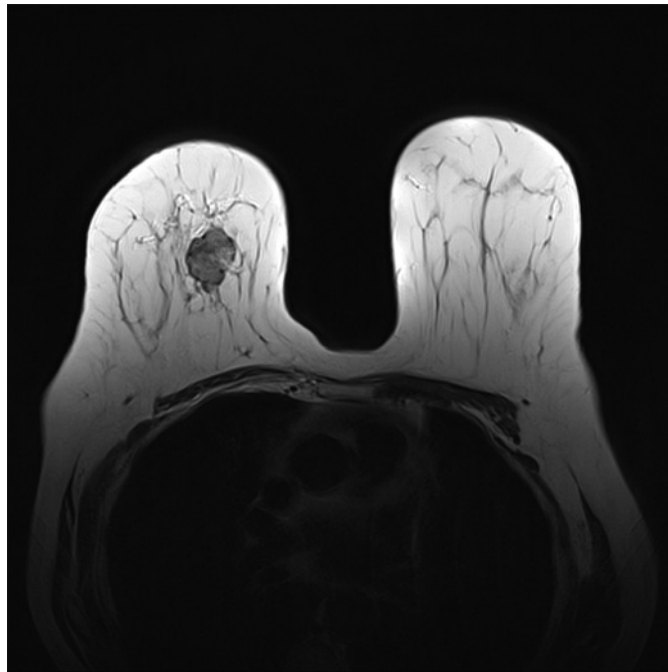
MRI of the right and left breasts.
